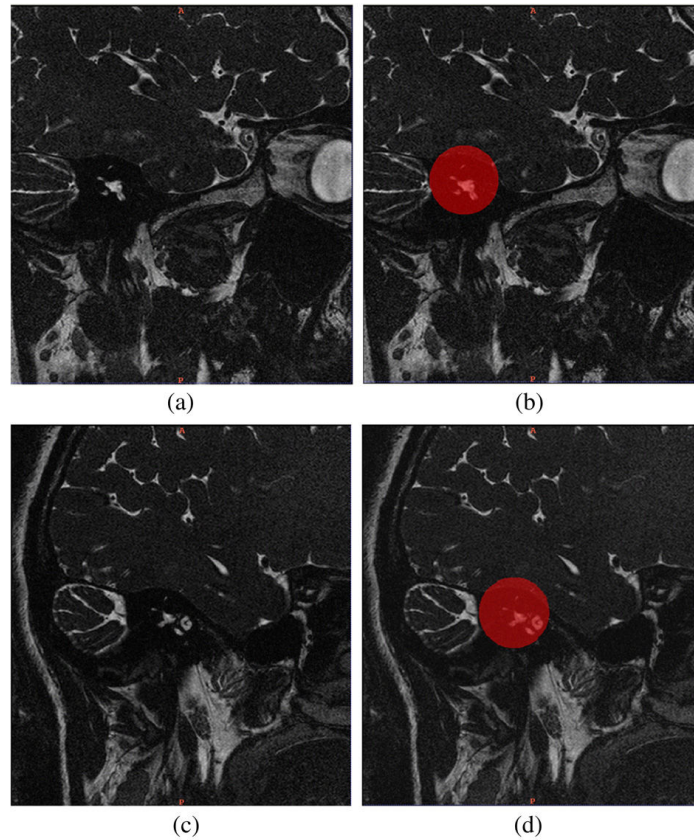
Temporal bone MRI sagittal slices (from [Shi 2011]). The cochlear region is indicated by semi-transparent red color.
